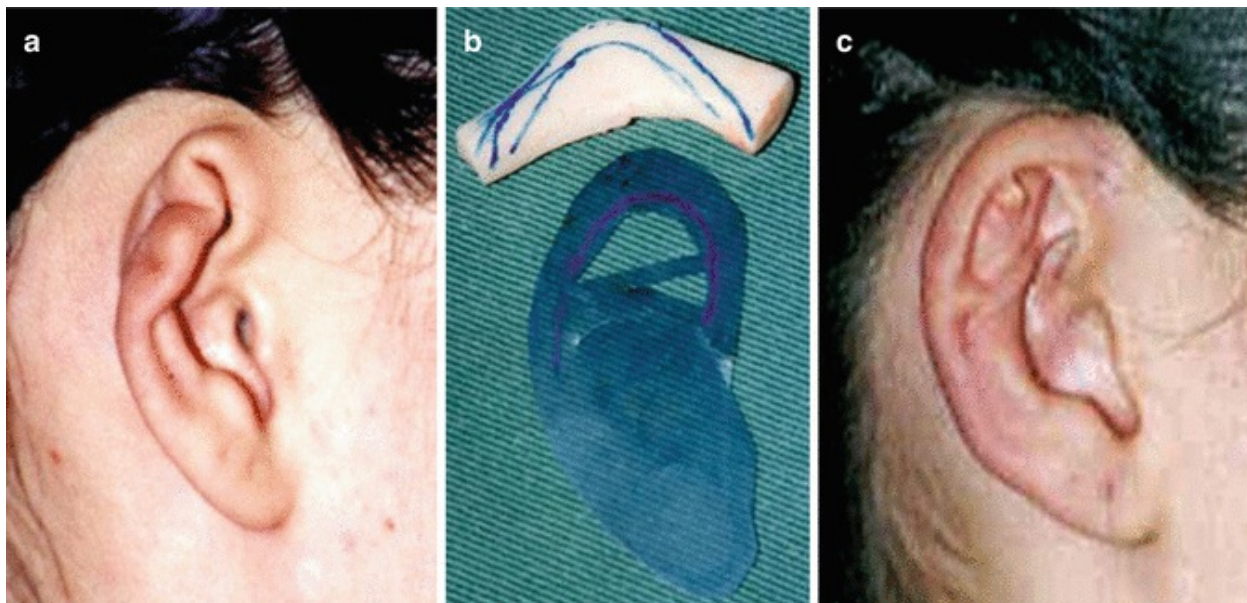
Partial destruction of the ear caused by infection due to piercing. (a) Pre-op photo of the right ear of a 19-year-old girl showing unesthetic skin retraction with severe damage to the ear cartilage; (b) surgical planning on an X-ray of the new auricular framework on a rib cartilage to create the missing segment; (c) the same patient after a one-stage reconstruction with insertion of the missing framework
